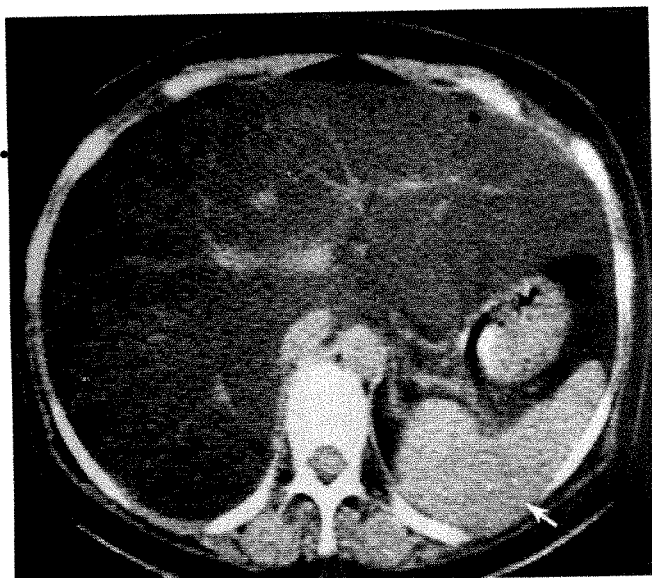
39-year-old woman with jaundice 4 years post jejunoileal bypass for obesity; bilirubin=5.3 mg/100 ml, alkaline phosphatase=980 U. CT scan showing striking difference in density between liver (4 EMI units) and spleen (arrow; 32 EMI units). No dilated bile ducts present within liver although vascular structures within liver clearly demonstrated. Findings diagnostic of diffuse fatty infiltration of liver.
